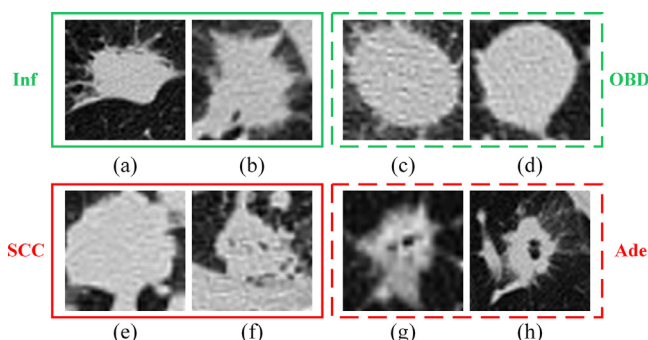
CT images of pulmonary nodules. The samples surrounded by green bounding boxes are benign, and those surrounded by red bounding boxes are malignant. (For interpretation of the references to colour in this figure legend, the reader is referred to the web version of this article.)
